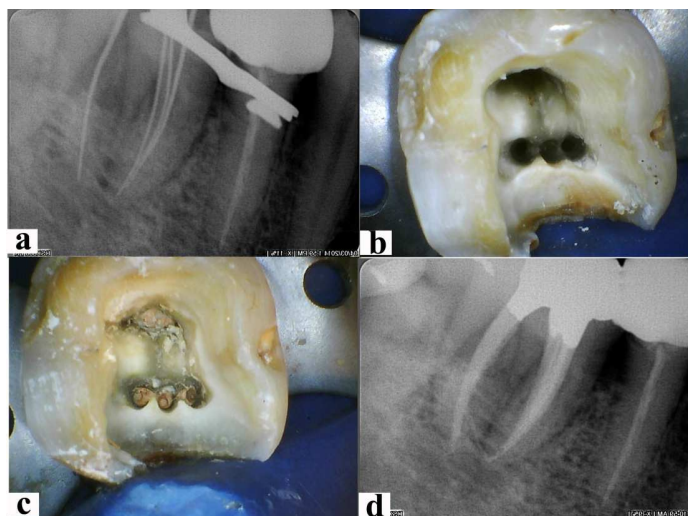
a) Working length IOPA radiograph showing the presence of middle mesial canal; b) Intraoral image showing the presence of middle mesial canal; c) satisfactorily obturated canals seen in the IOPA radiograph; d) clinical image showing obturated root canal orifices
